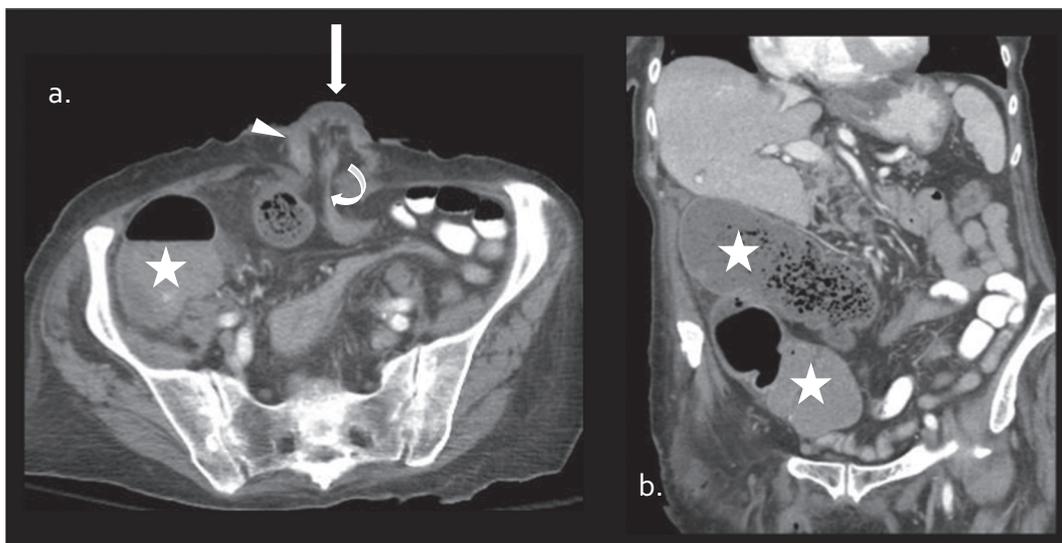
Stomal stenosis: axial (a) and coronal (b) images from a contrast enhanced CT scan demonstrates obstructed loop colostomy due to stomal stenosis. Note loop colostomy (arrow), proximal limb (arrowhead), distal limb (curved arrow), and obstructed right colon (star).
